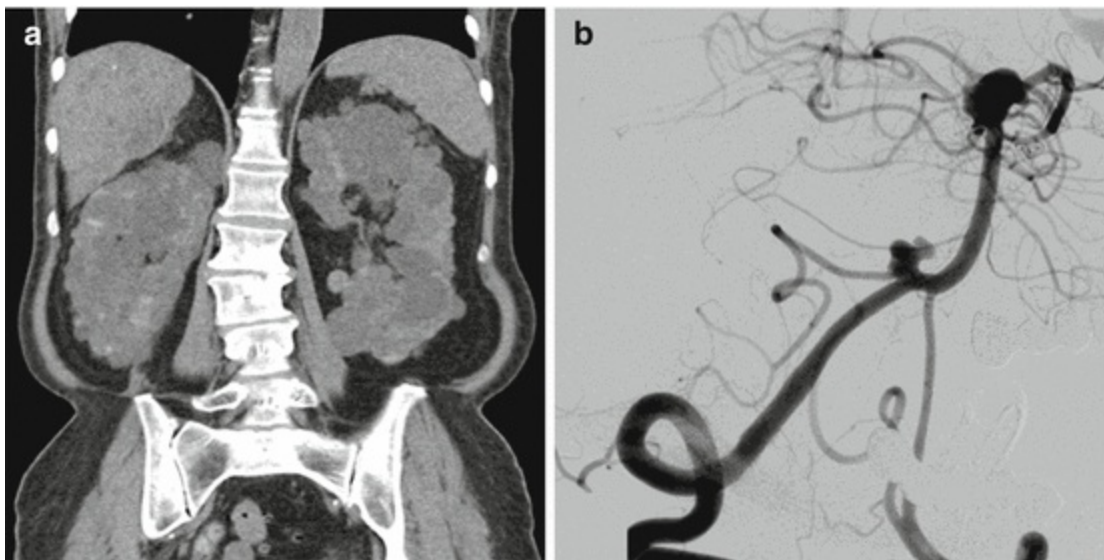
A 65 year old female with a history of ADPKD underwent screening MRA followed by cerebral catheter angiography. CT abdomen/pelvis shows (a) large kidneys with multiple renal cysts.
